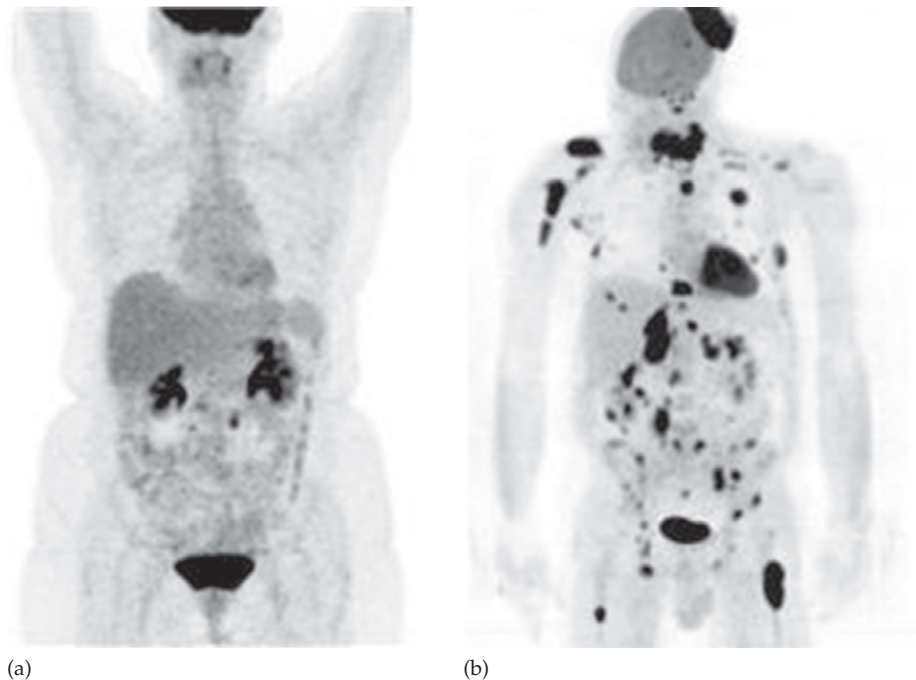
FDG-PET scans, maximum intensity projections. (a) Normal isotope distribution. There is intense uptake in the brain and the neck uptake is in the tonsils. The FDG is excreted by the kidneys. (b) Lymphoma, showing multiple visceral, nodal, bone and scalp deposits.
